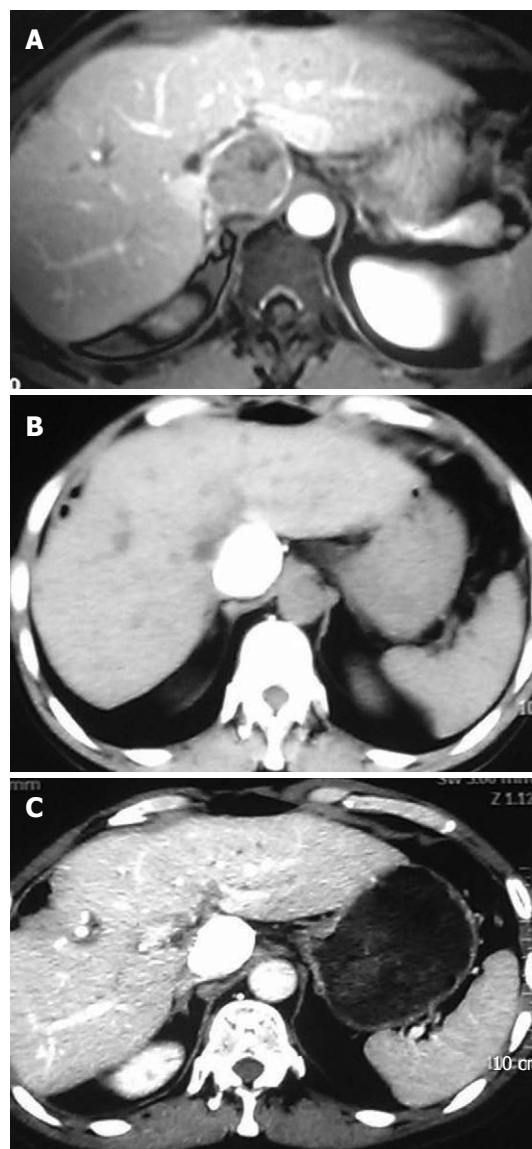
Contrast magnetic resonance imaging. A: A hypodense nodule with circle contrast manifestation after hepatectomy and the seventh Transcatheter arterial chemoembolization; B: Contrast computed tomography showing homogeneous dense retention of lipiodol within the entire tumor mass two months after treatment; C: Contrast computed tomography no recurrent mass 4 mo after treatment.
